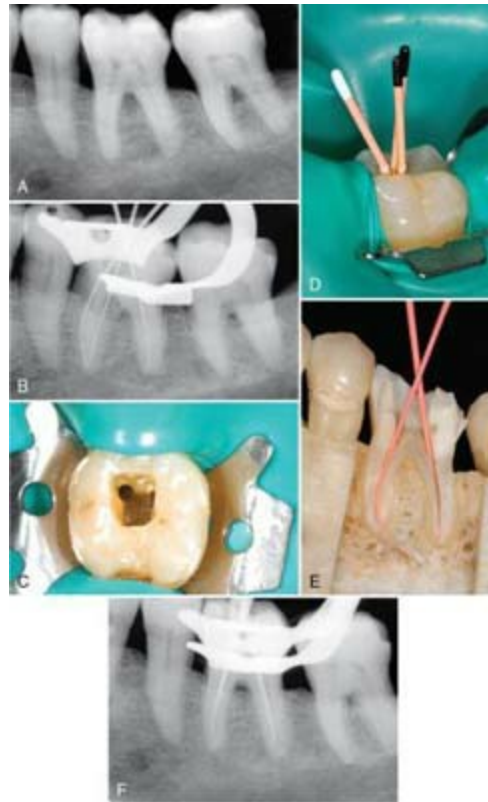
Left first mandibular molar. A, Pretreatment radiograph. B, Working length radiograph. C, Coronal access opening, demonstrating the prepared mesiobuccal canal. D, Standardized master cones with coronal reference marked. E, Standard master cones fit to length as they exhibit minimal taper and permit deeper penetration of the spreader. F, Master cone radiograph.
